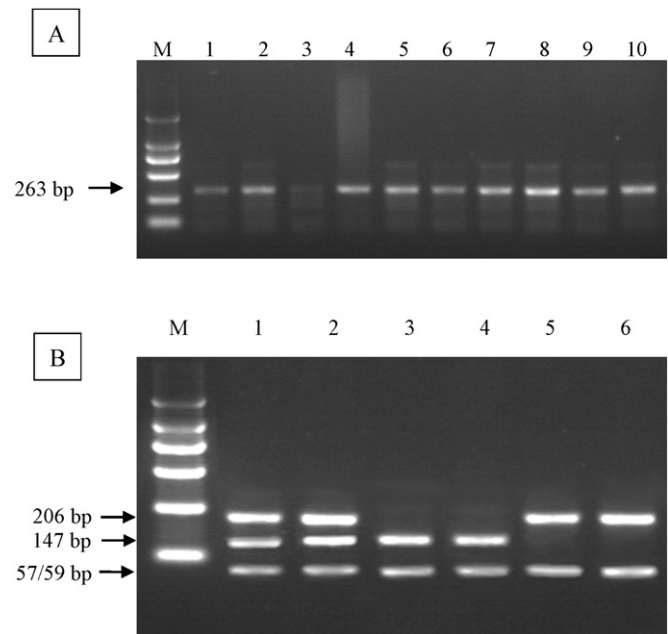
A, the PCR results of the polymorphism of *AKR1B1* gene. M, DL2000 DNA marker (100, 250, 500, 750, 1000, 2000 bp). Lanes 1–10 are amplification products of samples obtained from subjects. B, the PCR-RFLP results of polymorphisms of *AKR1B1* gene. M, DL2000 DNA marker (100, 250, 500, 750, 1000, 2000 bp). Lanes 1 and 2 are CT genotype (57, 59, 147 and 206 bp); Lanes 3 and 4 are TT genotype (57, 59 and 147 bp); Lanes 5 and 6 are CC genotype (57 and 206 bp).
